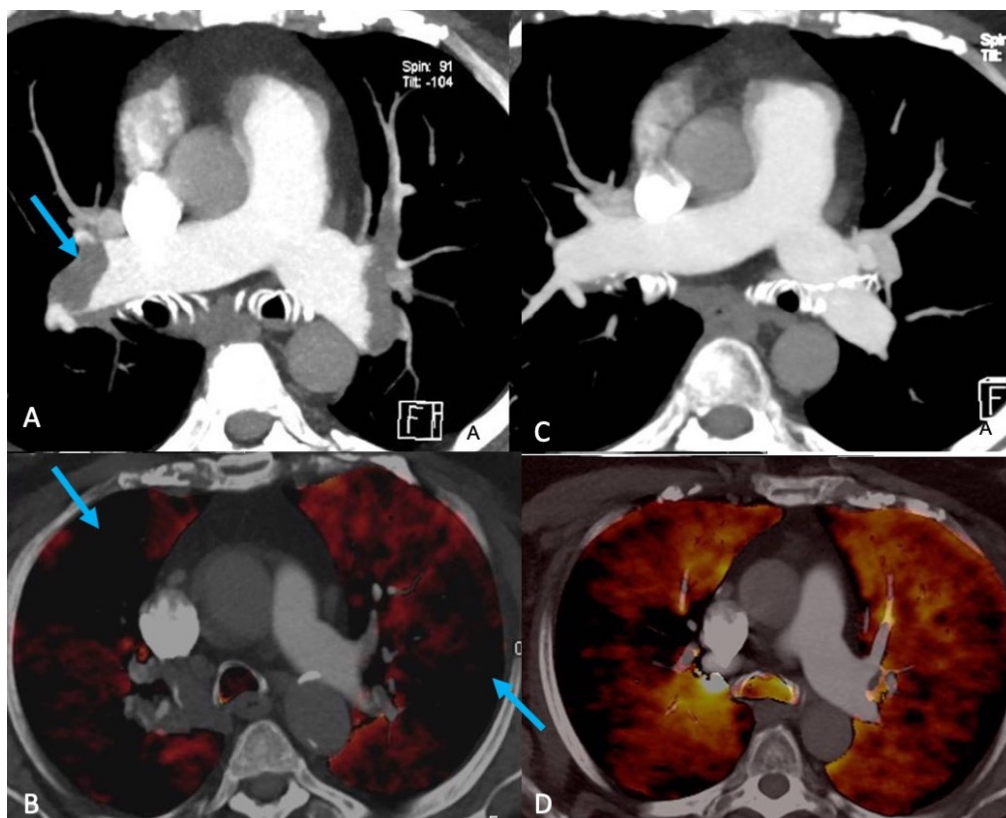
(A-D): Acute pulmonary thromboembolism. CT pulmonary angiogram (CTPA) (A) shows filling defects (arrow). The DECT perfusion map (B) shows bilateral perfusion defects (arrow). Three months after treatment, the CTPA (C) shows complete regression of the thromboembolism and the perfusion defects (D).
